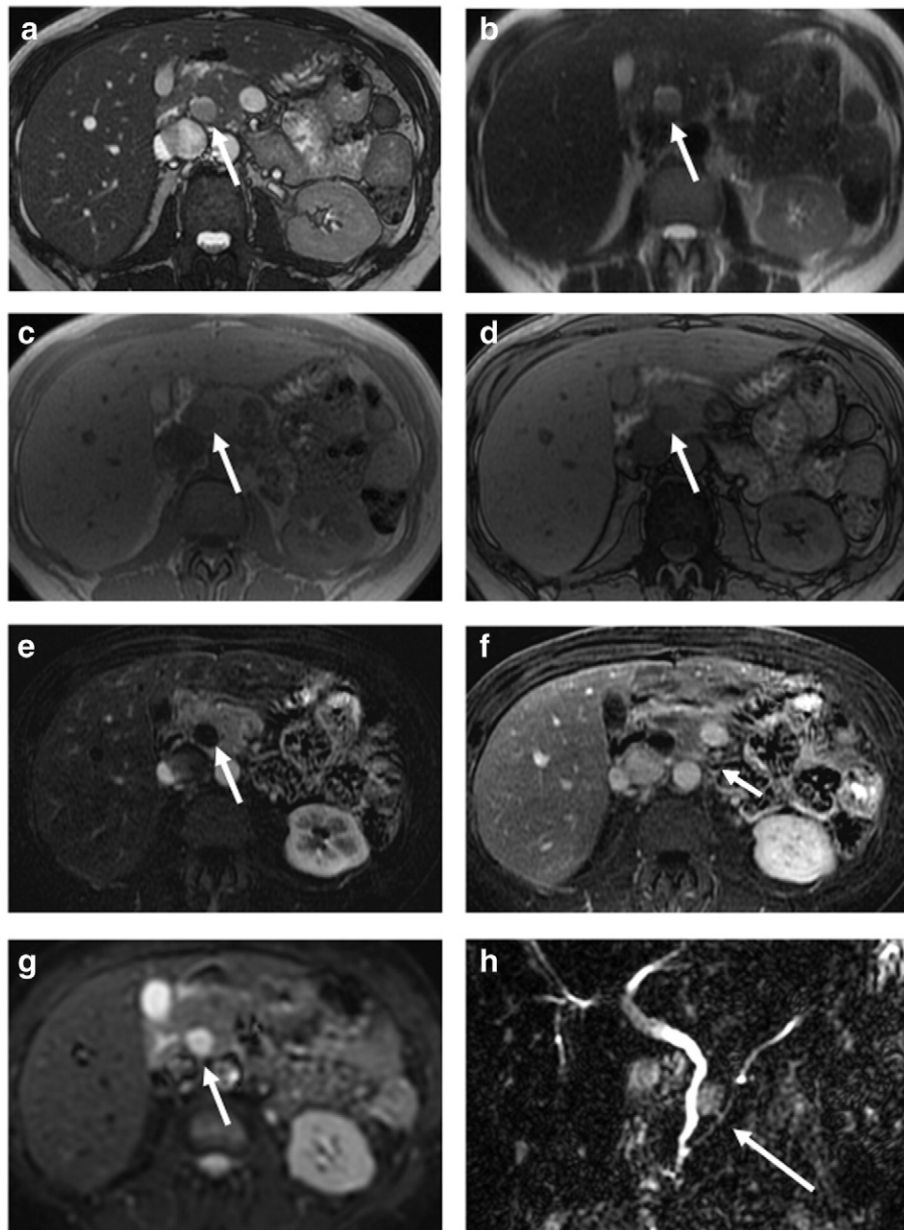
Contrast-enhanced MRI/MRCP of the pancreas. (a) Axial fast steady-state image shows a well-defined, round lesion located in the head of the pancreas (white arrow). (b) Axial T2-weighted image shows a slightly hyperintense lesion with some layering debris. (c) Axial T1-weighted in phase image demonstrates a mildly hypointense lesion, without signal loss on opposed phase image (d). Axial contrast-enhanced subtracted T1-weighted images during arterial (e) and portal venous (f) phases show lack of enhancement of the lesion. (g) Axial high-*b*-value DWI trace image demonstrates hyperintensity of the lesion. (h) Coronal 3D MRCP shows communication of the lesion with the pancreatic duct of Wirsung (white arrow), which is normal in caliber.
